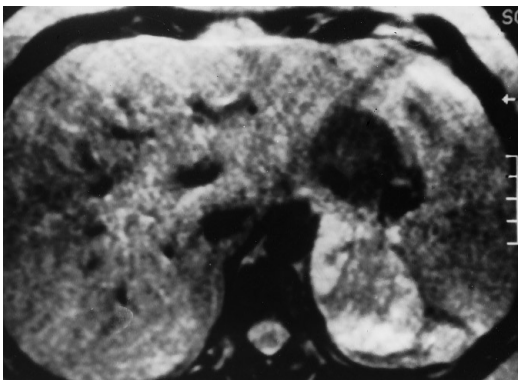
Axial fast spin-echo T2-weighted MR image. The left adrenal mass has an inhomogeneous high signal intensity indicating a prevalently colliquative configuration
